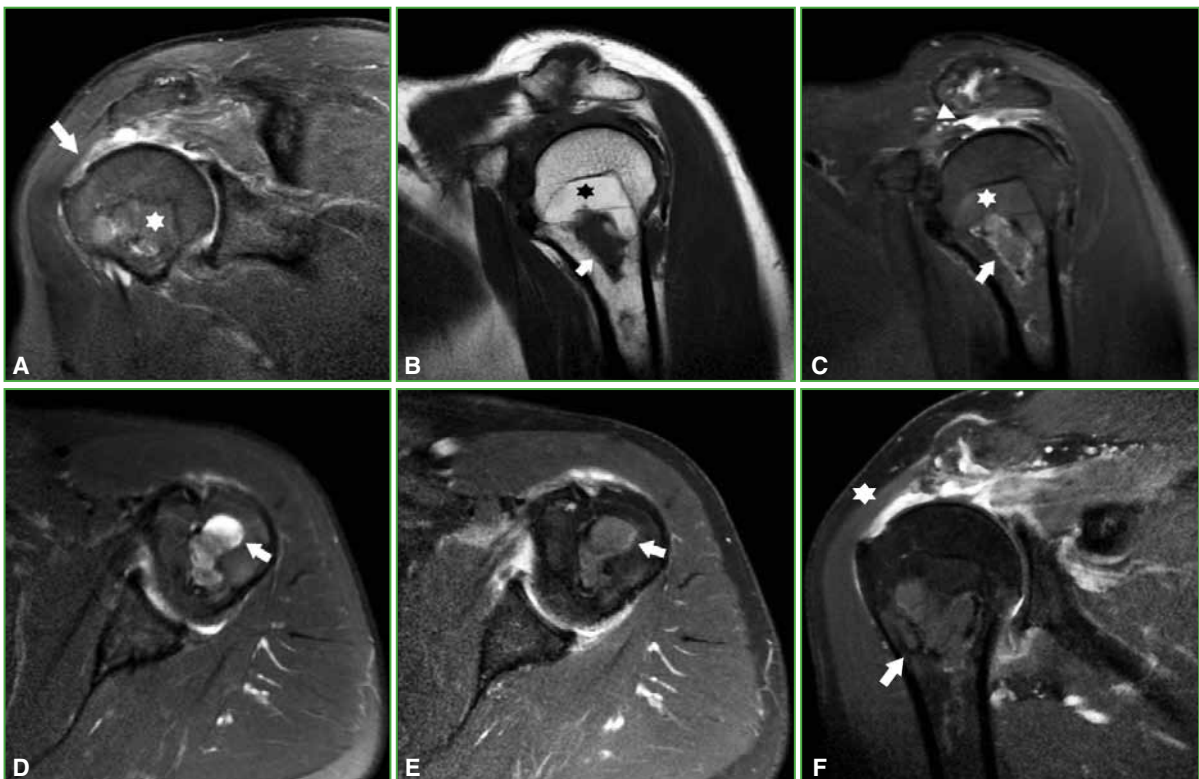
Left shoulder MRI. A. Coronal section in proton density sequence with fat suppression. Supraspinatus tear (arrow) and hypointense intraosseous lesion (asterisk). B. Sagittal section in T1 sequence. A predominantly hyperintense tumor (asterisk) with central hypointense lesion (arrow). C. Sagittal section in proton density sequences with fat suppression. The lesion becomes hypointense (asterisk) with its central component slightly hyperintense (asterisk). Supraspinatus injury. D. Axial section in proton density sequence with fat suppression. Heterogeneous central lesion, with a small cystic transformation (arrow). E. Axial section in T1 sequence with fat suppression and injection of contrast medium. Heterogeneous central lesion, with small cystic transformation (arrow) without enhancement after injection. F. Coronal section in T1 sequence with fat suppression and injection of contrast medium. Heterogeneous central lesion (arrow) without enhancement after injection. Supraspinatus injury (asterisk).
